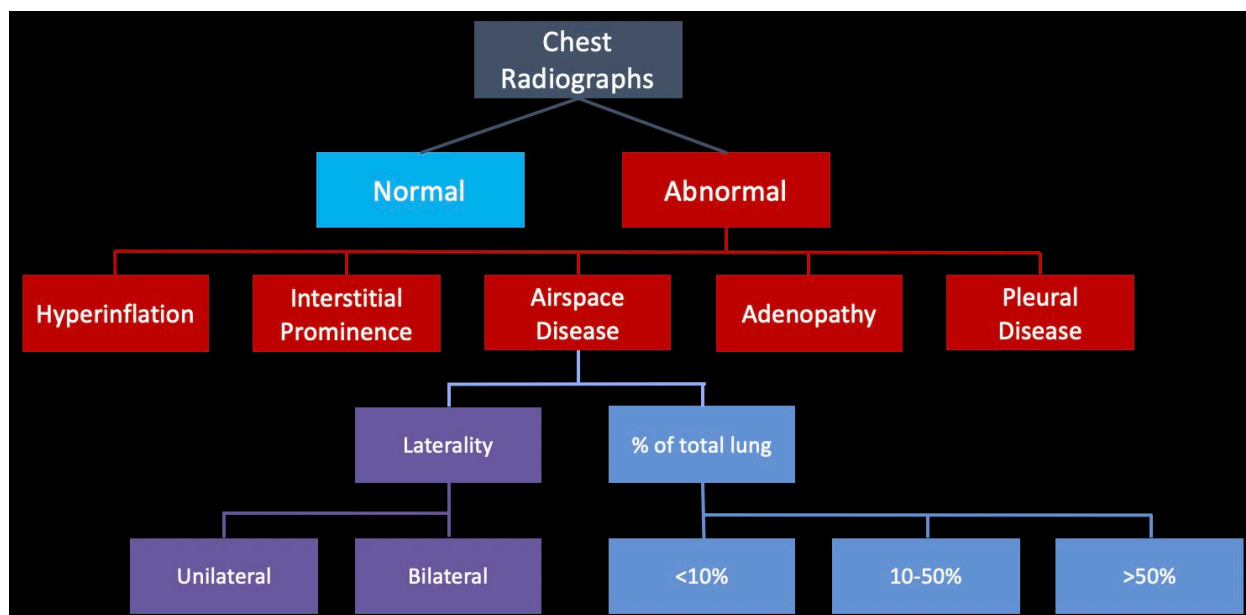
Radiological Review of RSV Admissions. Abnormal radiographs were reported as hyperinflation, interstitial prominence, airspace disease, adenopathy, pleural disease, and any combination of the above. Airspace opacities were further characterized by laterality (unilateral or bilateral) and percentage of total lung involved (<10%, 10-50%, and >50%).
